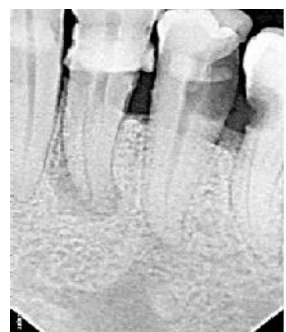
Preoperative radiograph 3rd Quadrant showing normal anatomy.
